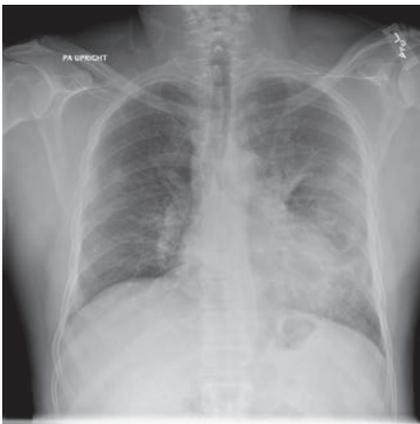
Chest radiograph at ED presentation and hospital day 3 showing progression to severe ARDS.
